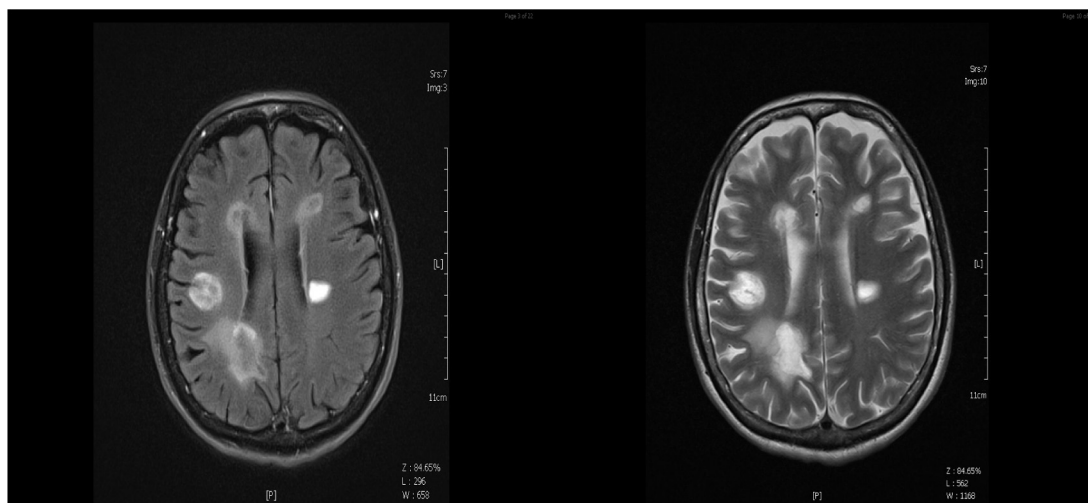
Three months after initial presentation, brain MRI showed a new symptomatic enhancing lesion in the left frontoparietal region. At the same time, initial lesions were reduced in volume along with the resolution of surrounding edema.
